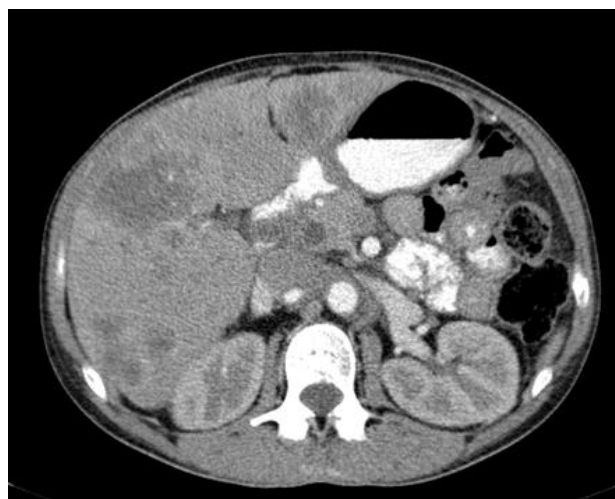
CT scan with intravenous contrast shows multiple liver metastasis.
